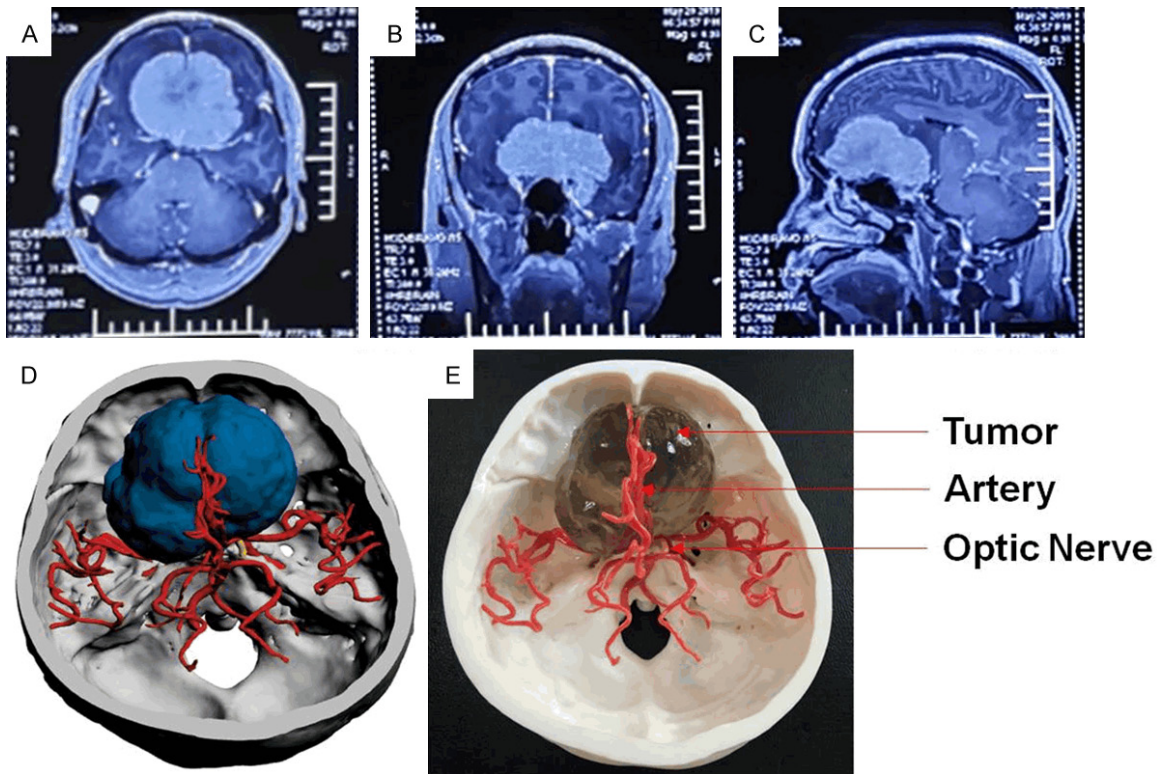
3D-printed model for the huge meningiomas. T1-weighted MRI scan (A: Axial scanning; B: Coronal scanning; C: Sagittal scanning), 3D digital reconstruction (D) and 3D-printed model (E).
